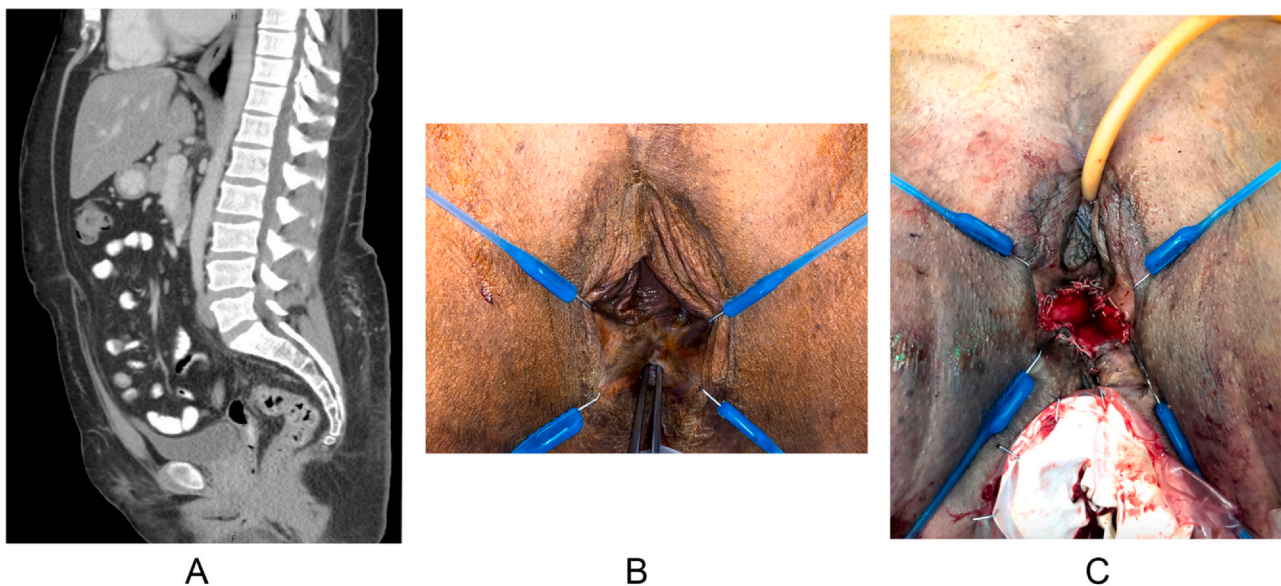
(A) Patient 4 computed tomography of the abdomen and pelvis demonstrating neovaginal stenosis with distention of the proximal neovagina. (B) Patient 4 intraoperative clinical image demonstrating neovagina with stenotic ring preventing dilation. (C) Patient 4 intraoperative clinical image demonstrating reconstructed vaginal canal. (Color version available online.)
